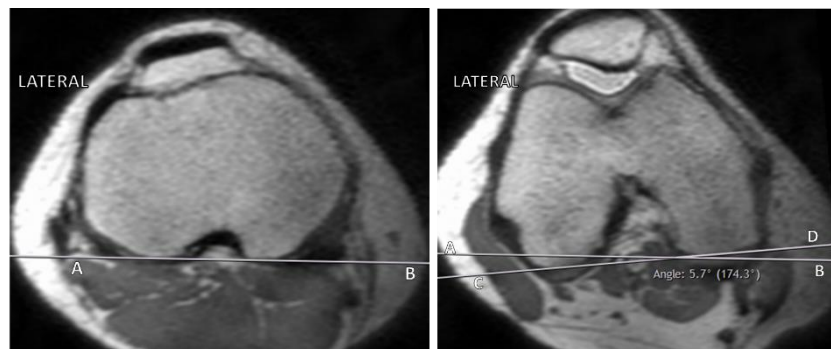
Measurement of knee rotation on MRI. (a) An axial section through the proximal tibia with clearly recognised posterior condylar notch was chosen. Posterior tibial condylar line AB was drawn. (b) An axial section through the distal femur with a well-defined Roman arch and deepest point of trochlea was chosen. Posterior femoral condylar line CD was drawn. Knee rotation was measured as the angle between lines AB and CD.
